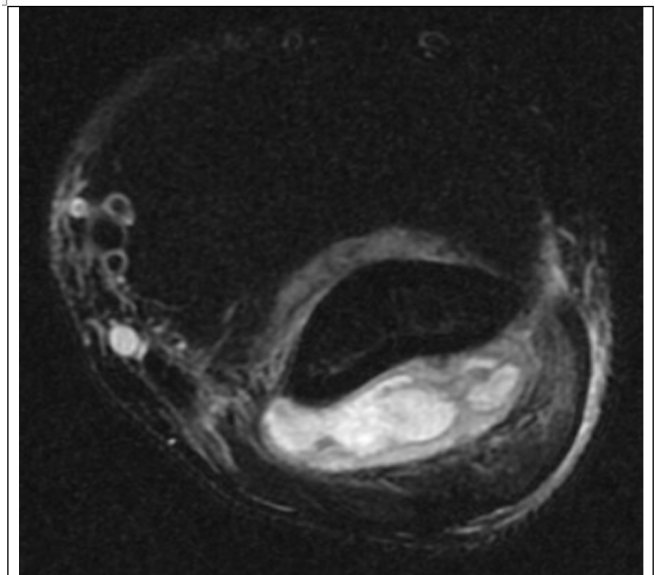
Axial T2-weighted fat-suppressed magnetic resonance image of the left elbow showing a multiloculated joint effusion with synovial thickening and surrounding soft tissue edema, most pronounced near the flexor-pronator origin, consistent with septic arthritis.
